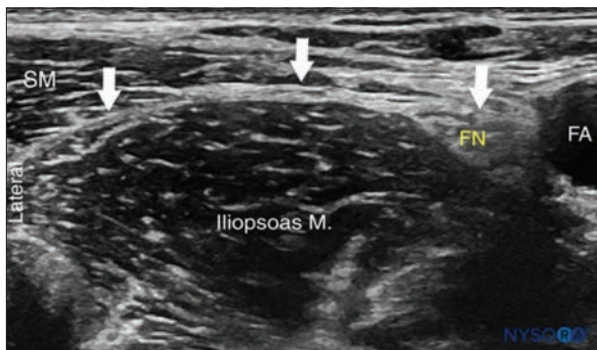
Ultrasound image at the level of the inguinal ligament of the femoral nerve situated lateral to the femoral artery, above the iliopsoas muscle, and beneath the fascia iliaca. Source: NYSORA.com.^[15] Permission to use this figure was granted by NYSORA.
